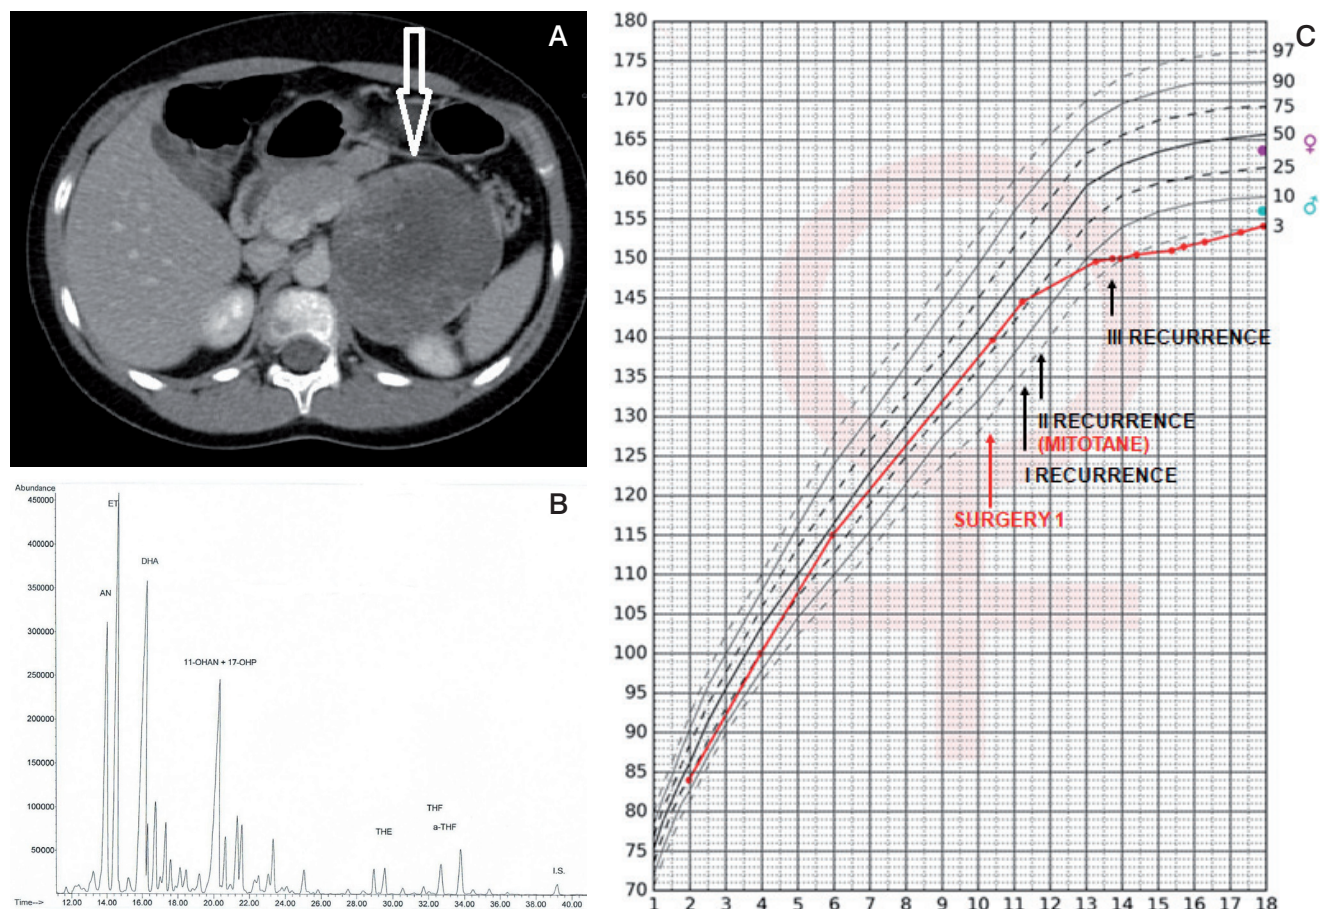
A) Computed tomography of the abdominal cavity demonstrating a tumour in the left adrenal cortex (size 96 × 73 × 86 mm). B) Chromatogram of the urinary steroid profile (24 h) at diagnosis suggested an adrenocortical tumour producing excessive delta 5 androgen and cortisol metabolites of the steroid profile in the 24-hour urine collection. C) Patient's percentile grid with marked moments of surgery and recurrences. Final height at the 3rd c.
